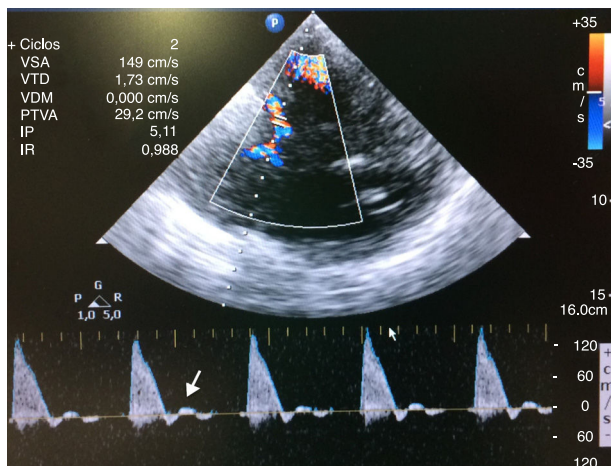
Transcranial color-coded duplex ultrasound recording. Systolic flow in left middle cerebral artery. Note the absence of diastolic flow (white arrow).
